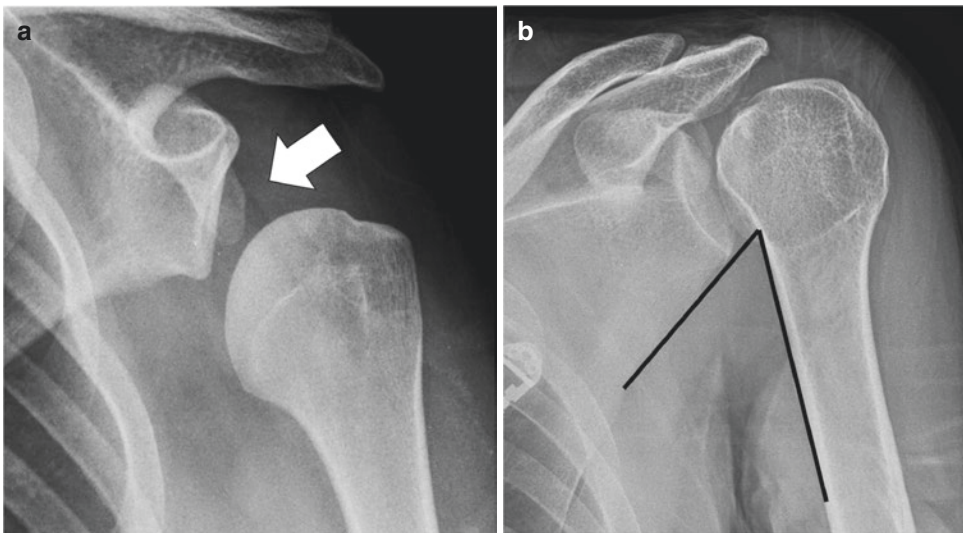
Radiographic signs associated with a posterior shoulder dislocation. (a) A rim sign is present when the glenohumeral joint measures greater than 6 mm in width (arrow). The humeral head does not have to sublux inferiorly or superiorly for this sign to be present. (b) This scapulohumeral arch
